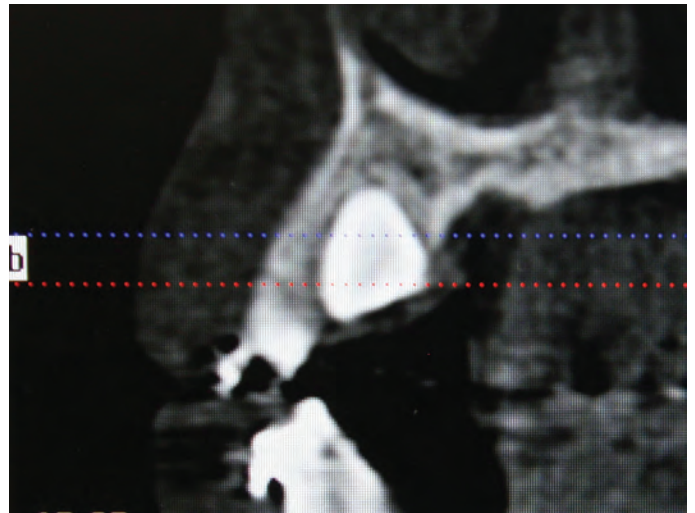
Cone beam computed tomography sagittal view demonstrating the palatal position of tooth #6.
